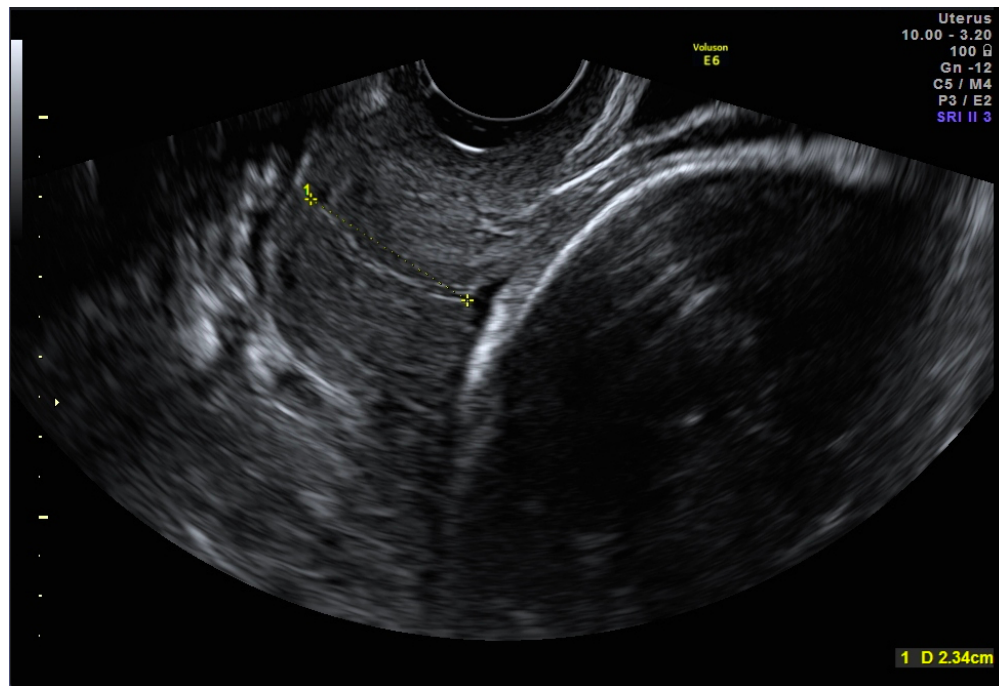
Transvaginal ultrasound assessment of normoechoic membranes with the fetus in cephalic presentation
